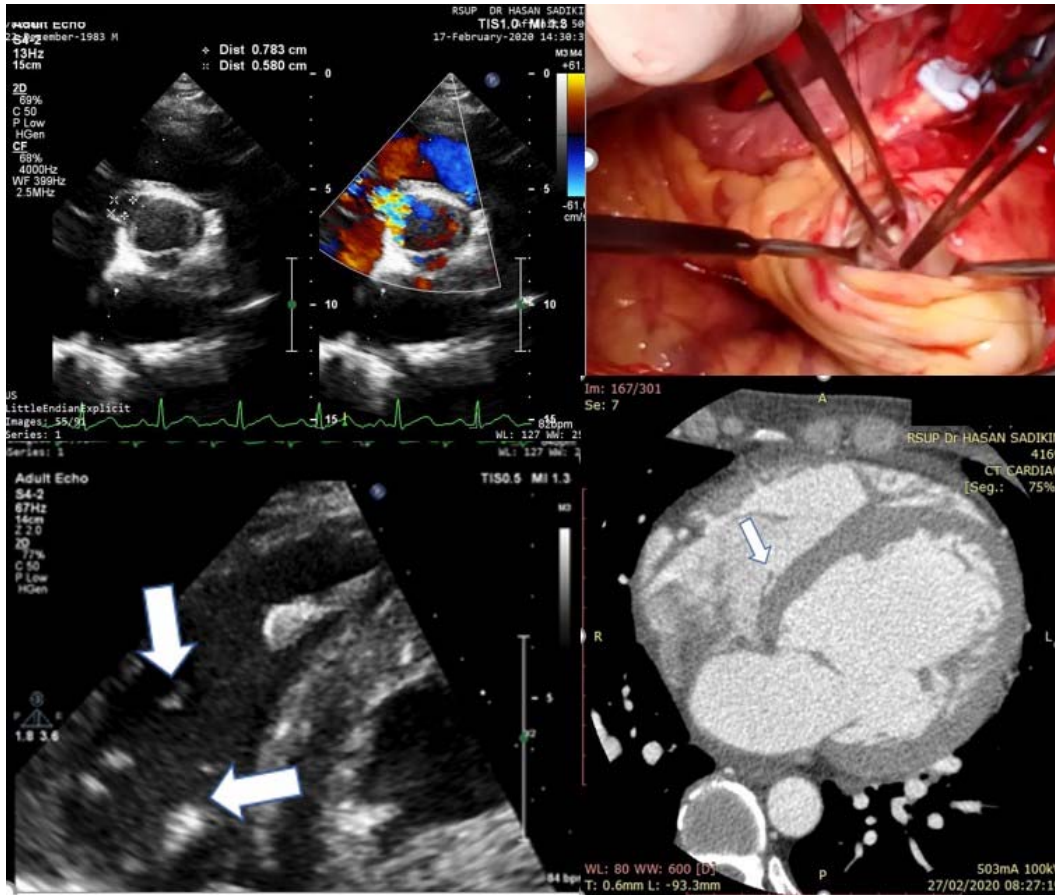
Ruptured sinus of Valsalva (RCC to RA) showed by echo (upper left) and intra operation (upper right) and multiple small vegetations attached to tricuspid valve by echo (lower left) and cardiac CT Scan (lower right) showed by arrow
